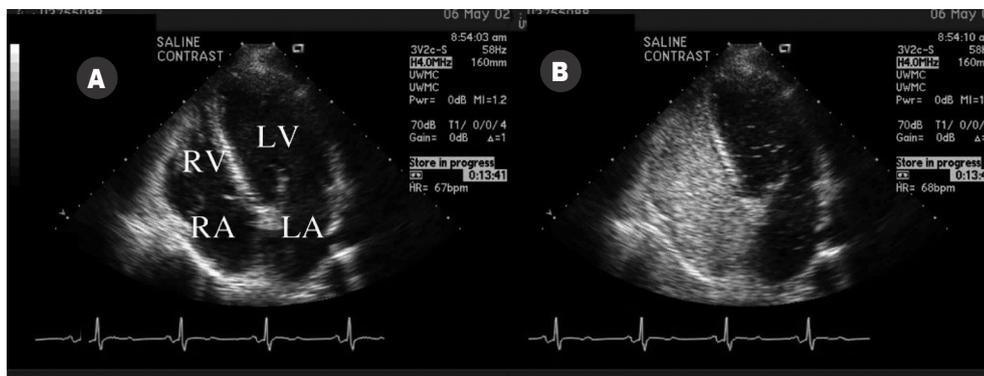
TTE in a 29 year old woman with sudden diplopia. Apical four chamber view before [A] and after [B] intravenous agitated saline injection. Note opacification of the right heart chambers and the presence of microcavitations in the left heart chambers, which indicates right-to-left shunting at the atrial level.
